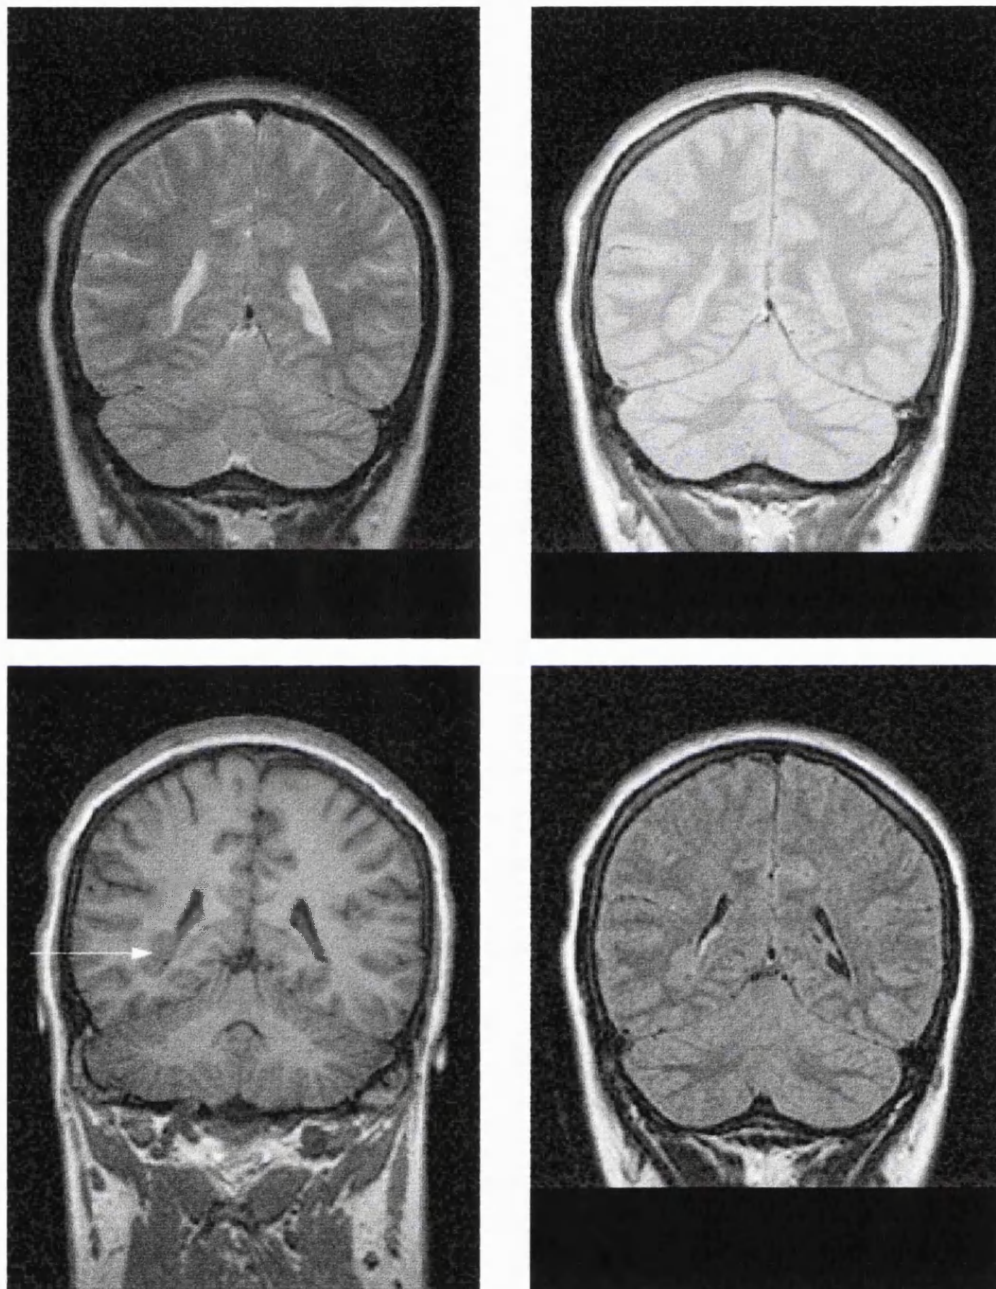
NODULAR SUBEPENDYMAL HETEROTOPIA. Coronal spin echo T2-weighted image (top left), proton density weighted image (top right), T1-weighted image (bottom left) and fast FLAIR image (bottom right). Ectopic grey matter is shown adjacent to the right ventricle (arrow). The signal intensity of the ectopic grey matter is similar to normal grey matter and not more conspicuous on fast FLAIR. The patient had partial epilepsy.
